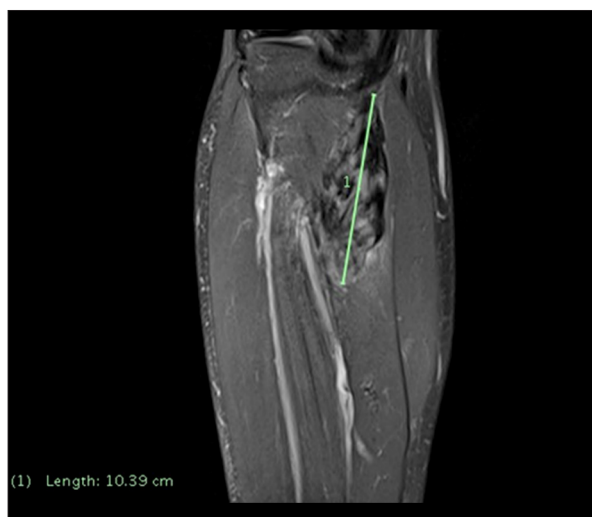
MRI image sagittal calf.
